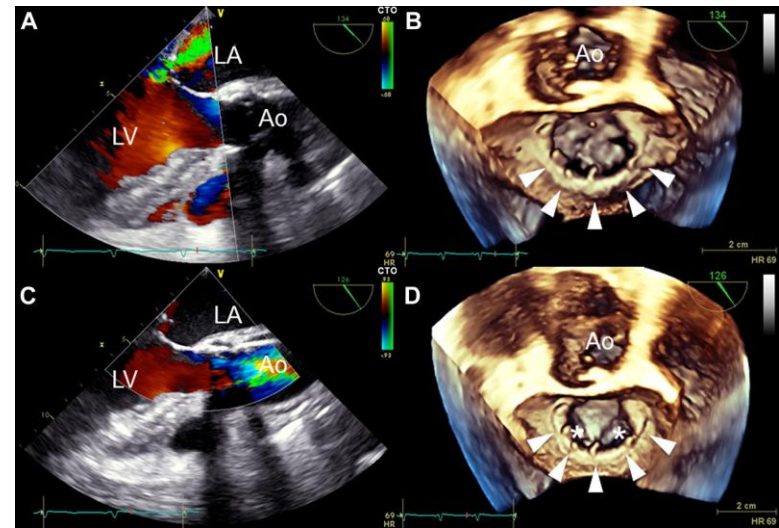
Transesophageal Echocardiography Before and After the Procedure From a Representative Case (Patient #6)
